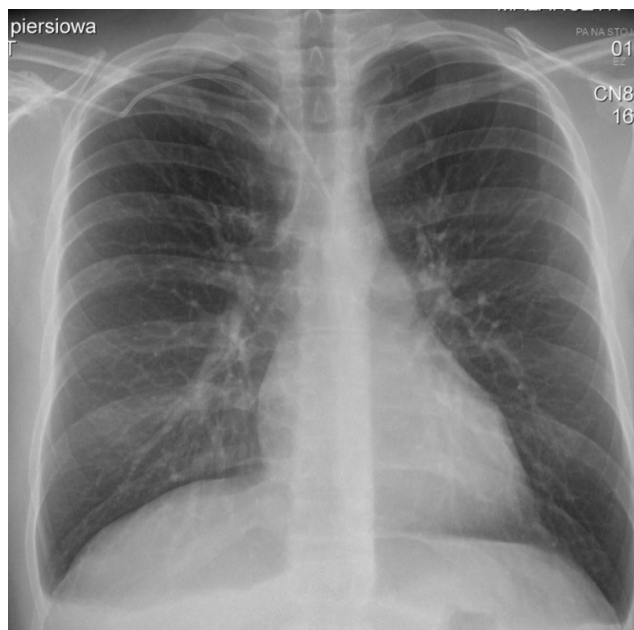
The X-ray of the misplaced catheter – arterial injection.
